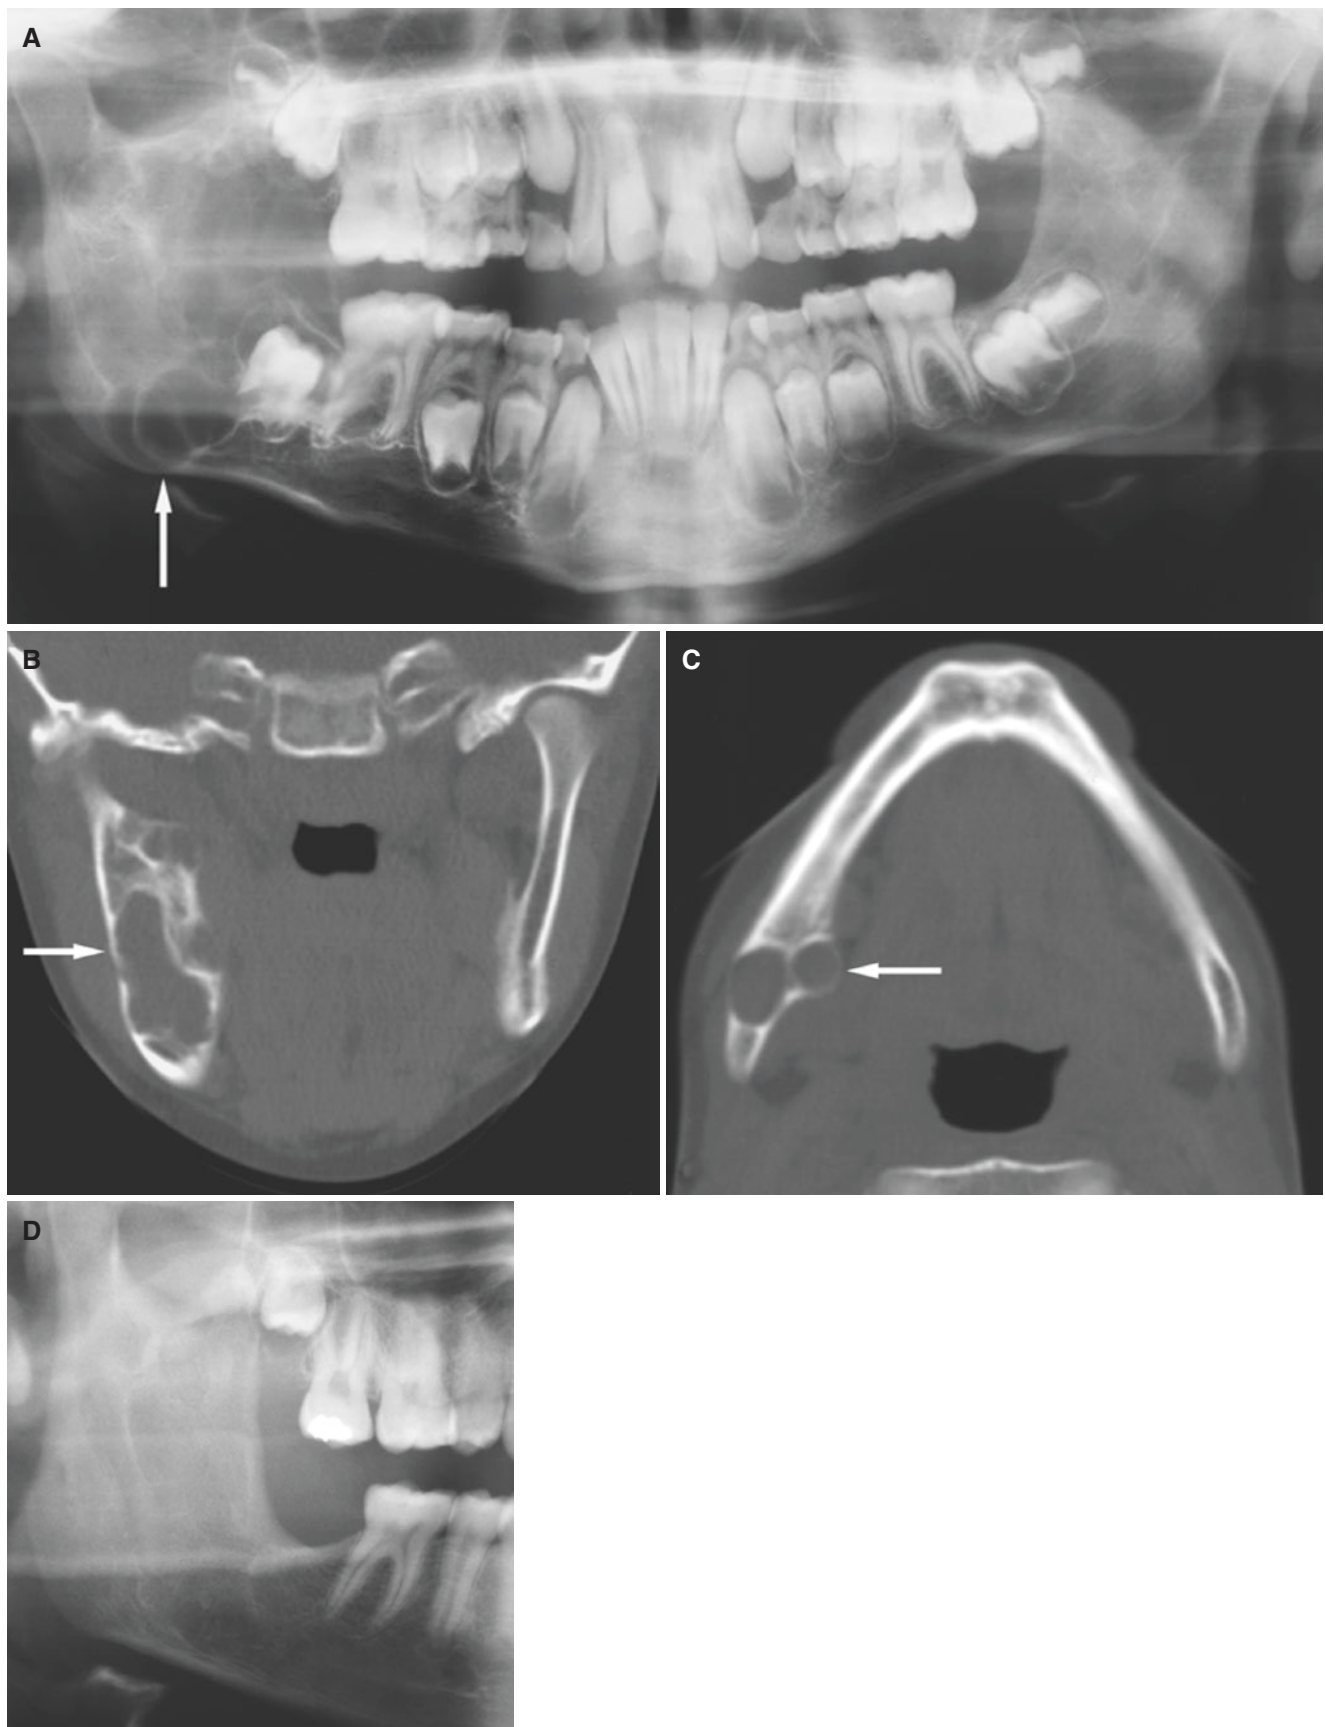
Giant cell granuloma, mandible; 10-year-old male at presentation with painless jaw swelling. (A) Panoramic view shows multilocular radiolucency with sclerotic border (*arrow*). (B) Coronal CT image shows expansive, multilocular process (*arrow*). (C) Axial CT image
